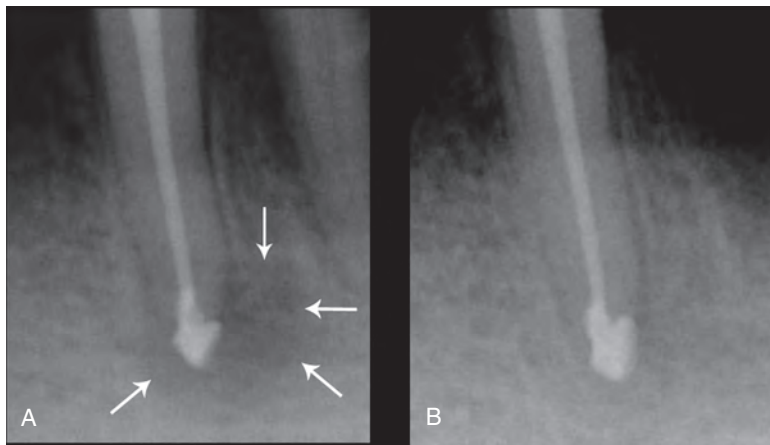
Healing of the periapical lesion after the Apexum procedure. A, The immediately postoperative radiograph; note the accidental major extrusion of the obturation material, a single case of its type in the whole study. Arrows indicate the extent of the lesion. B, Follow-up radiograph at 2 months. Metzger Z et al. J Endod 2009;35(2):158. Reproduced with permission.
